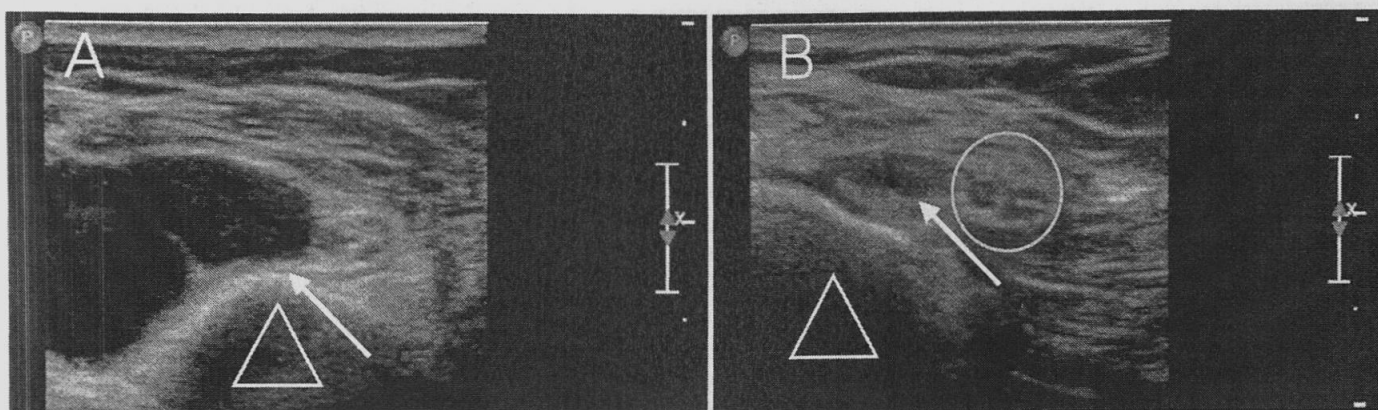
Intraneural ganglion cyst of the peroneal nerve. A: Cyst within the articular branch just rounding the fibular head (*white triangle*) with dorsal through transmission characterizing cyst fluid in the ultrasound image (*white arrow*). B: The same nerve just proximal to the fibular head, where the articular branch joins the common peroneal nerve (*white arrow* and *yellow circle*). Figure is available in color online only.
